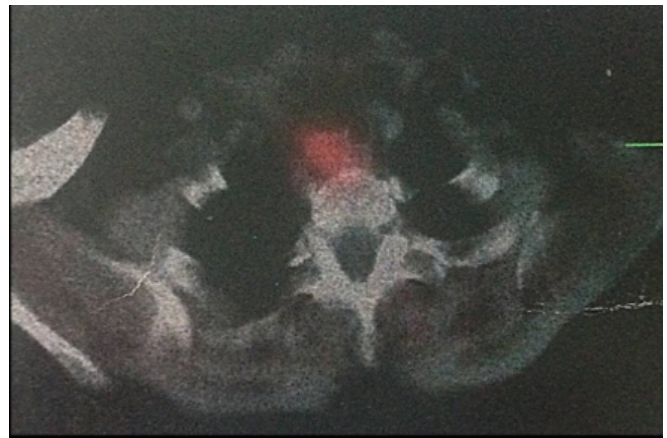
Parathyroid scintigraphy showing the lesion.
